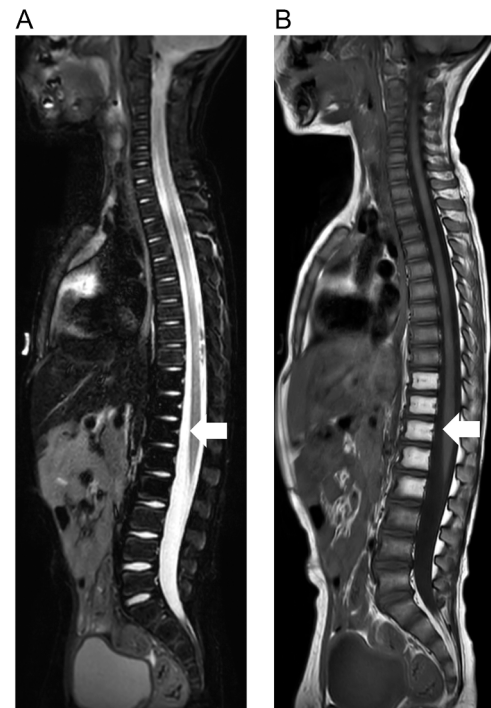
Sagittal STIR (A), and T1w (B) MRI images in a boy, 4 years of age, with a neuroblastoma for which he was treated with chemotherapy, surgery, and radiotherapy. Follow-up 4 months after end of radiotherapy shows complete fatty replacement of the bone marrow of the lower thoracic and upper lumbar vertebrae with a sharp demarcation and pronounced low signal intensity on STIR (arrow in A), and high signal intensity on T1 (arrow in B).
